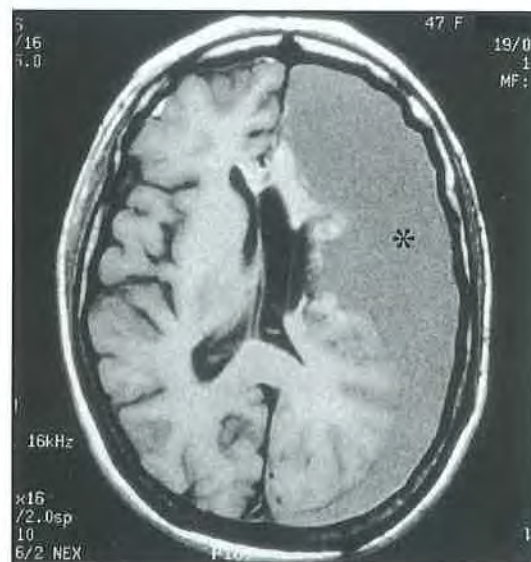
In this T1 weighted axial MRI image, a large left sided subdural haematoma (asterix) is noted to cause severe compression of the adjacent brain
